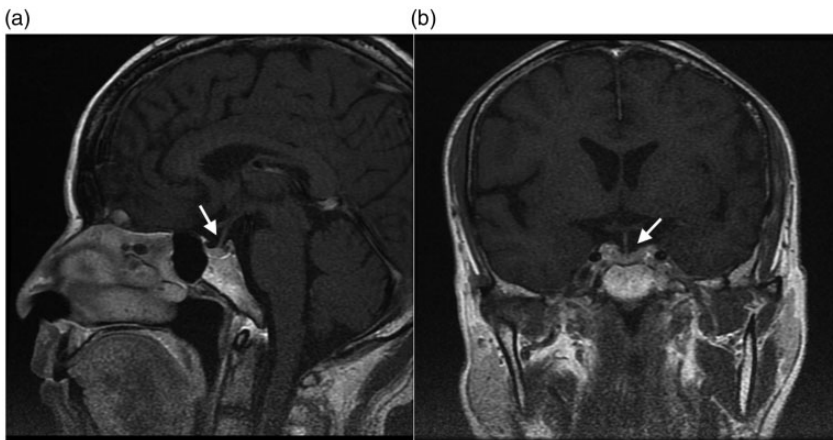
Intracranial MRI of the patient demonstrated no abnormalities in the hypothalamus, pituitary gland, or pituitary stalk. The white arrow indicates that the pituitary gland and pituitary stalk were a normal size. Left image (a), sagittal view; right image (b), coronal view.
